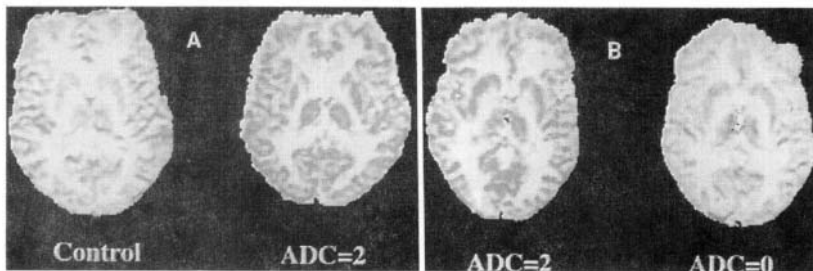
Representative dynamic contrast functional MRI images of normalized cerebral blood volumes at the level of the basal ganglia. The scale goes from white to yellow to red, which represents low to moderate to high relative blood volume. (a) Dynamic cerebral blood volume (CBV) image from a healthy control subject (left) and an HIV-positive patient (right) with moderate dementia (ADC Stage 2). Increase in the cortical and deep gray dynamic CBV in the patient with dementia is apparent. (b) Functional MRI images from the same patient obtained before (left) and after (right) 6 months of treatment with zidovudine. Improvement in dementia (ADC Stage 2 to 0) with treatment was accompanied by a reduction in the cortical and deep gray matter dynamic CBV.
